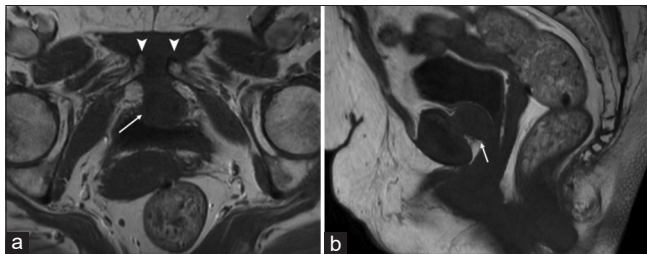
T1-weighted MR images in axial (a) and sagittal (b) plane show the lesion as isointense to the muscle (white arrow) and in continuity with the symphyseal cartilage. White arrowheads show pubic diastasis.
